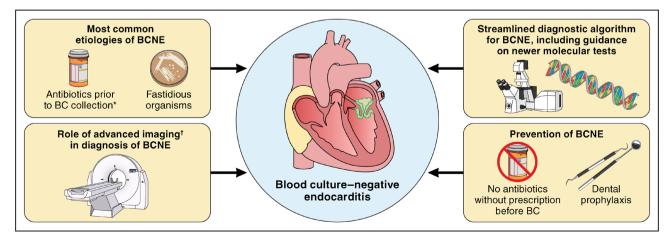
Blood culture-negative infective endocarditis. BC indicates blood culture; and BCNE, blood culture-negative endocarditis. *Antibiotics before BC collection remain the number 1 cause of BCNE. [†]Advanced imaging refers to mainly fluorine-18-fluorodeoxyglucose positron-emission tomography/computed tomography.
